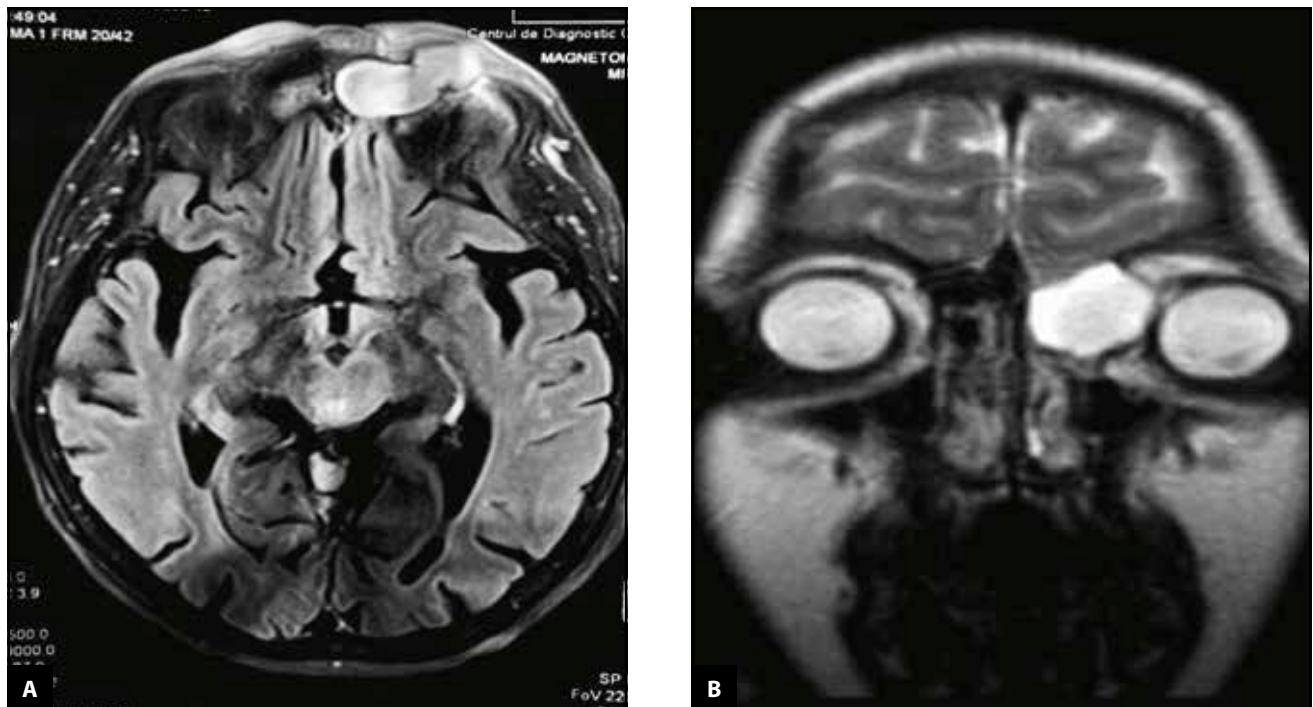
Cranio-facial MRI scan: A – axial slice shows the suspected mucocele in the left frontal sinus and ethmoidal cells; B – coronal slice identified a hyperattenuated homogenous expansile lesion originating from the left ethmoid sinus with left intraorbital extension.
